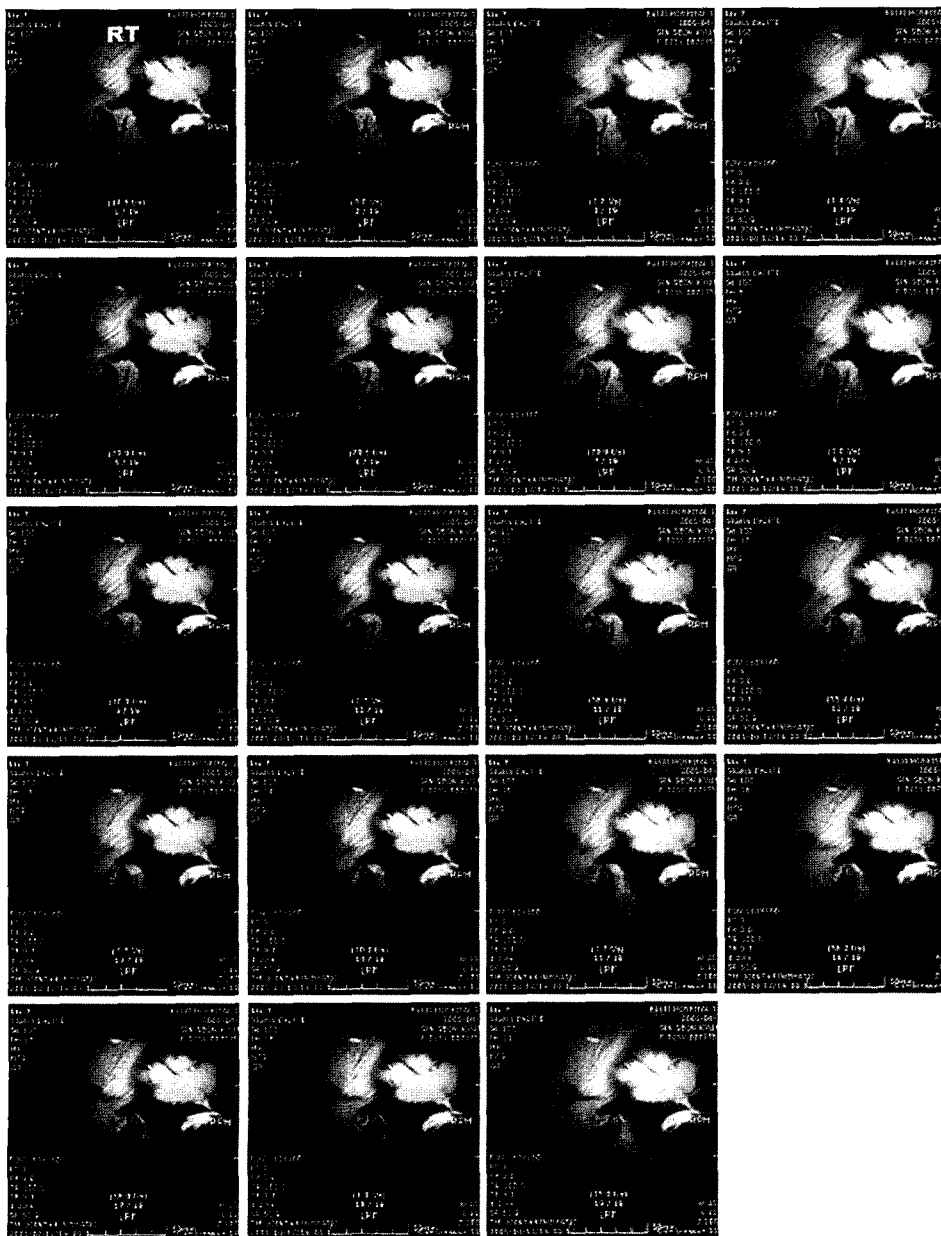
The pseudo-dynamic MRI of TMJ ID without reduction.
